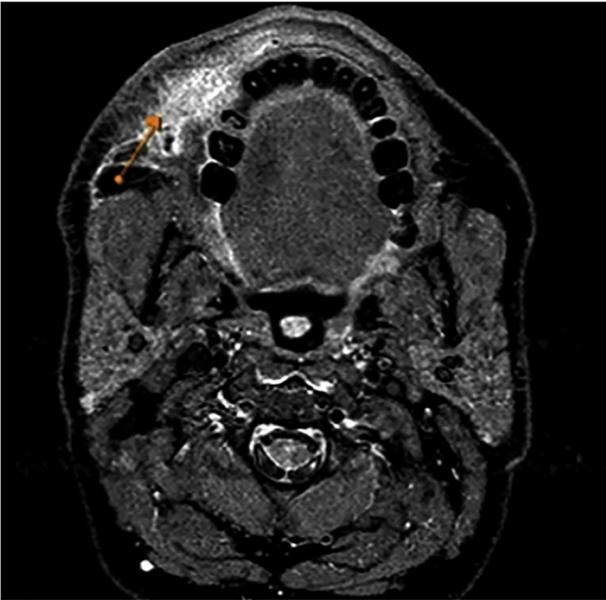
Axial T2w/STIR MR image shows well-defined lesion with high signal intensity (arrow) and increased signal intensity of surrounding diffuse inflammation.
